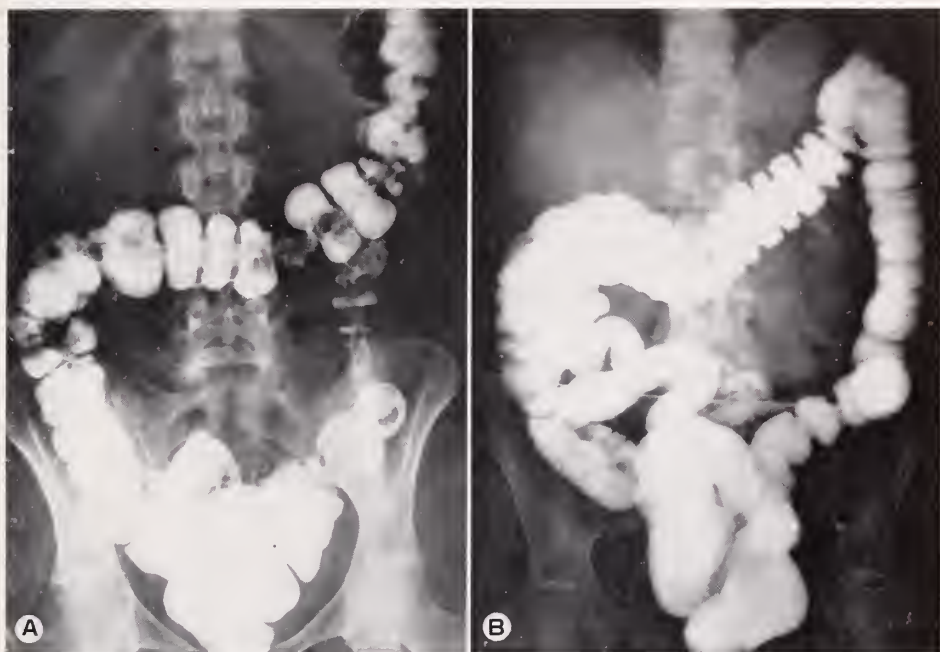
Reversibility in ulcerative colitis. Same case as Fig. 1 and 2, six months later. Remarkable reversibility in appearance of the colon. There is no roentgen evidence of an inflammatory process. The haustral markings are within normal limits. A moderate amount of stool is present in colon due to incomplete preparation.
